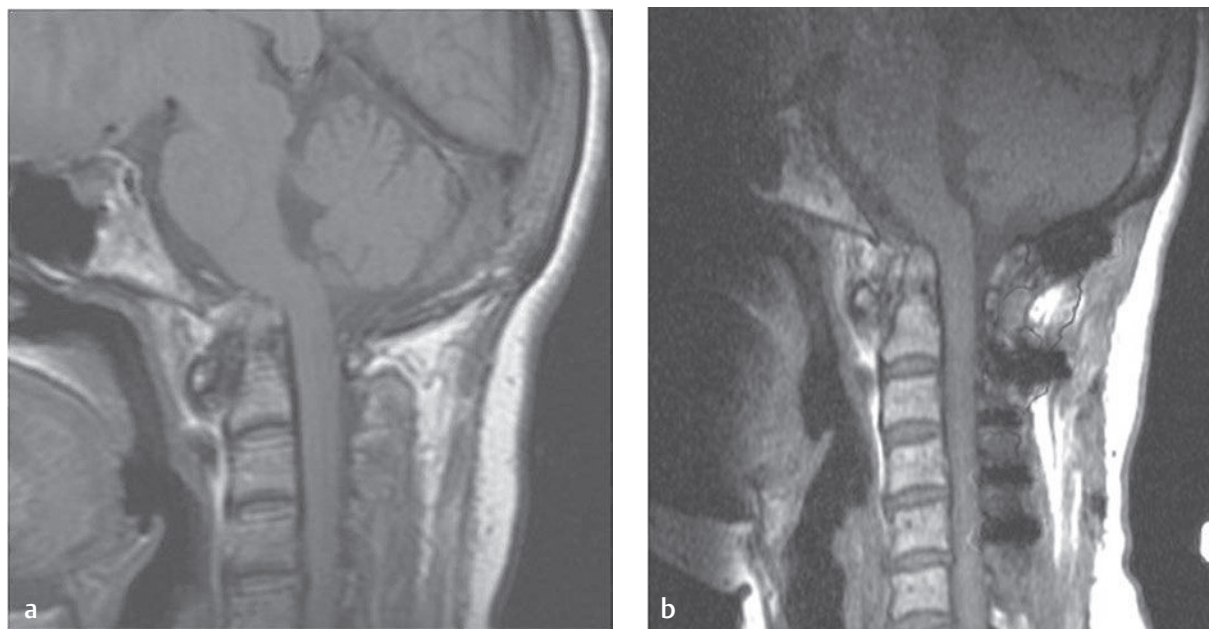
Cranial settling. (a) A sagittal T1-weighted image shows cranial settling in a patient with RA. (b) A sagittal T1-weighted image with metal suppression after instrumented reduction from the occiput to C5, which resulted in decreased brainstem compression.
